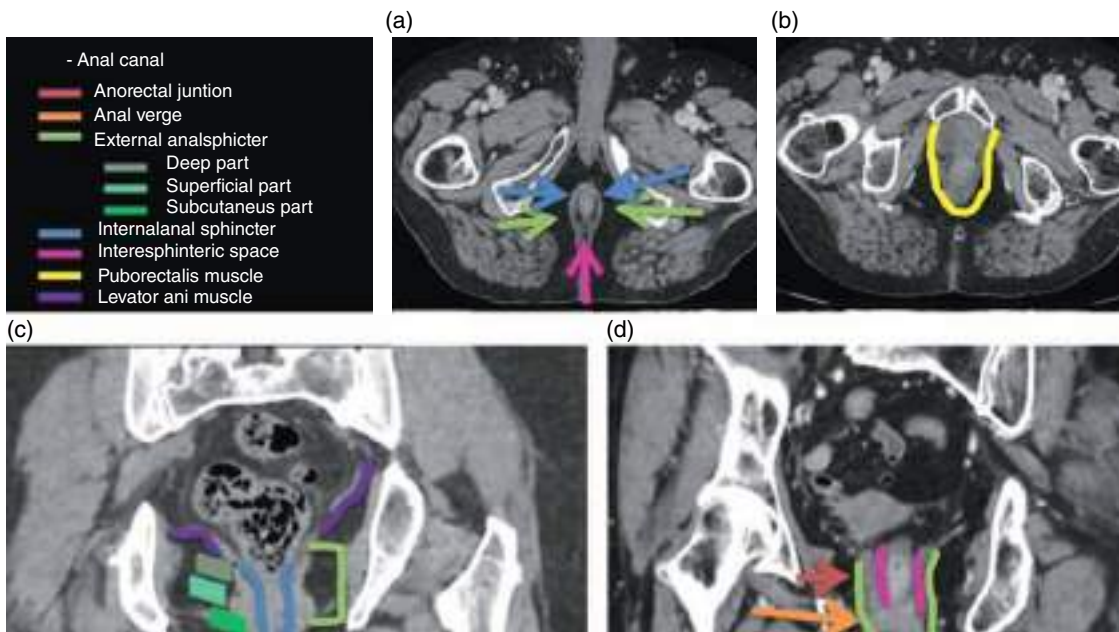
Anal canal. (a, b) Axial noncontrast CT images. (c) Coronal noncontrast MPR CT image. (d) Coronal contrast-enhanced MPR CT image (portal venous phase).
